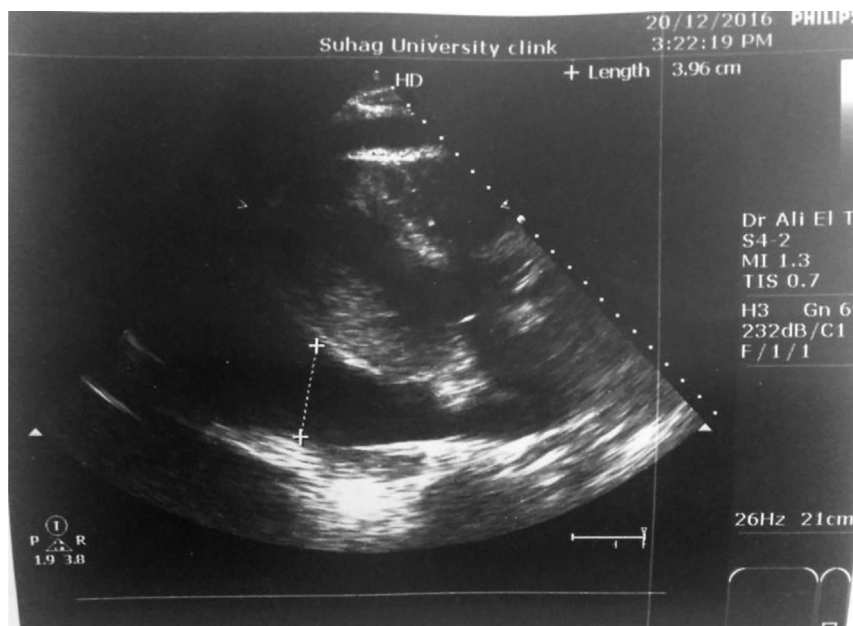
Transthoracic echo of massive pericardial effusion.
